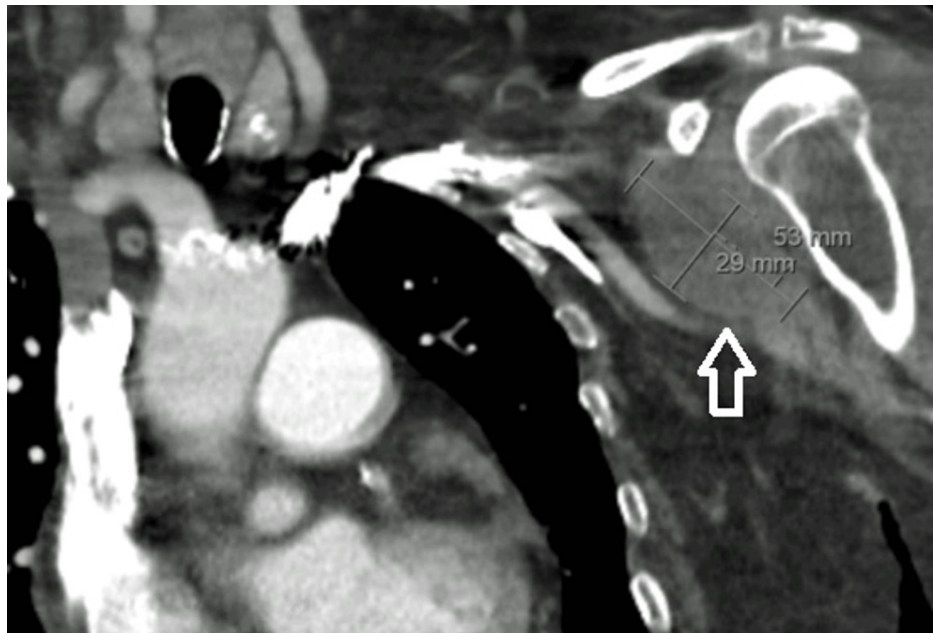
Left shoulder CT scan showing hypodense fluid collections.
